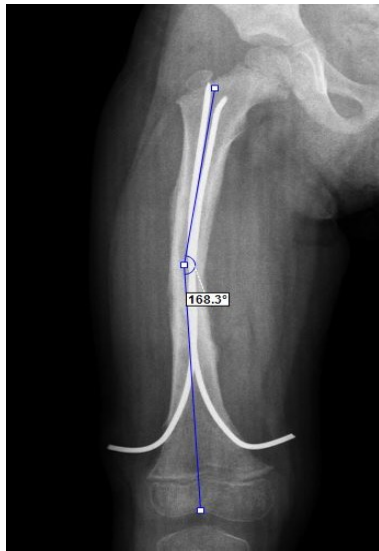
Anterior posterior femur radiography at the postoperative 1st month of the patient undergoing titanium elastic nailing surgery.
